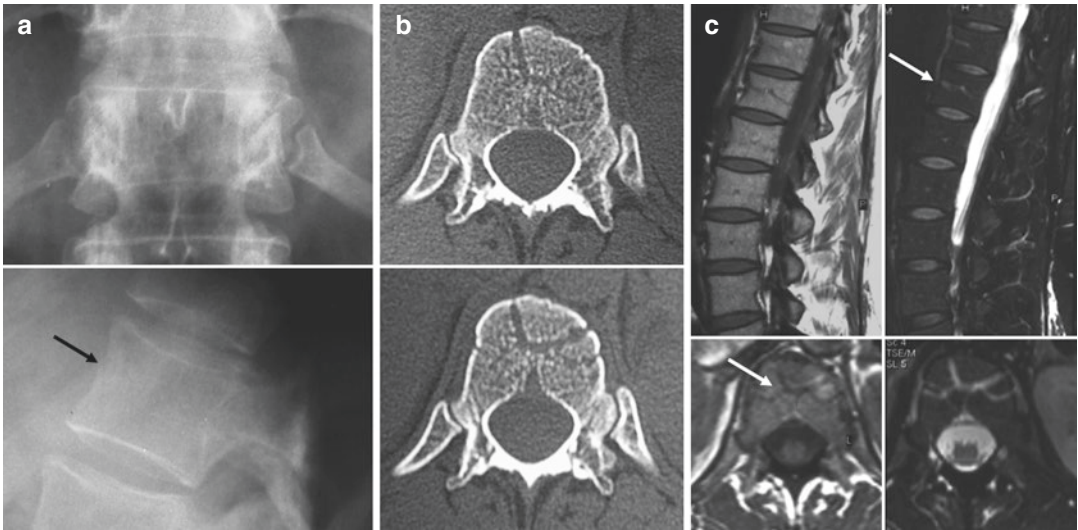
Basivertebral veins: anteroposterior and lateral radiographic views (a), consecutive axial CT images (b), and T1-weighted and fat-suppressed T2-weighted sagittal and axial MR images (c). Radiography shows a subtle radiolucency (*black arrow*) along the anterior wall of T12 vertebral body; this finding was considered suspicious for fracture after a skiing fall. CT clearly depicts the vertebral body basivertebral veins which course horizontally
